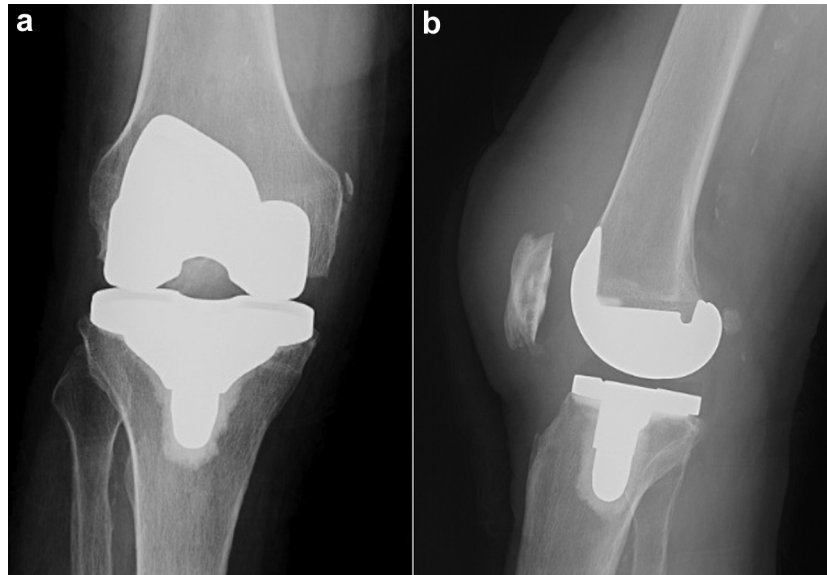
Postoperative AP (a) and lateral (b) radiographs 2 weeks after patient 1 underwent a right total knee arthroplasty with VMO advancement.
